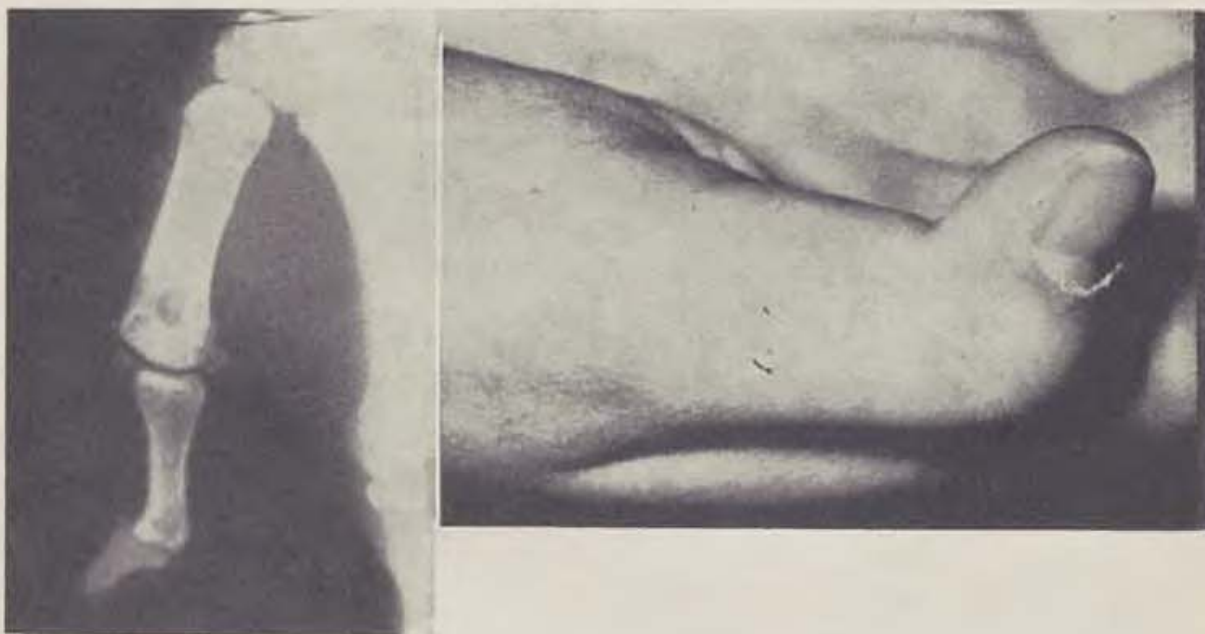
Axial deformity of the right hand thumb after removal of duplicated distal phalanx in a 17 year old girl, patient R. M., born 1958, No. clin. notes 37 317. — Fig. 2. X-ray picture of the thumb in the same patient
